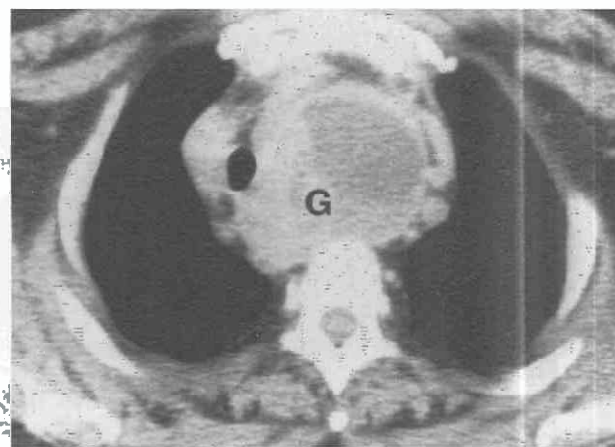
Mediastinal goiter. Contrast-enhanced CT shows large goiter (G) displacing the trachea to the right, and the left common carotid and subclavian arteries to the left. Enhancement is heterogeneous.
